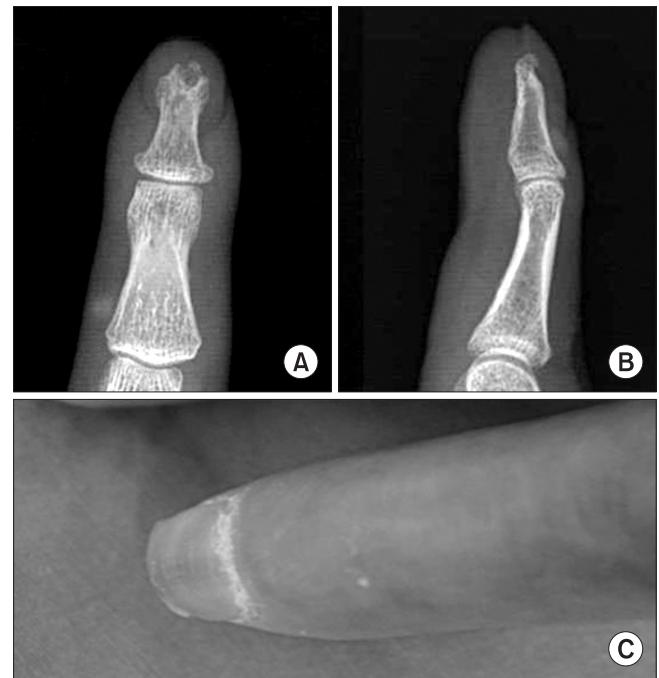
(A, B) Anteroposterior and lateral radiographs 14 months after curettage show diminished radiolucent lesion and progression of union compared with previous radiographs. (C) Gross finding shows nail deformity 14 months after operation.
